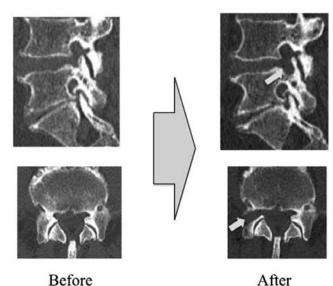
Computed tomography scans before and after the full-endoscopic ventral facetectomy at the level of right L4-5. Arrows indicate the area of the foraminoplasty, and the sufficient decompression of the right foramen and lateral recess at L4-5; ventral aspect of superior articular process of the L5.
